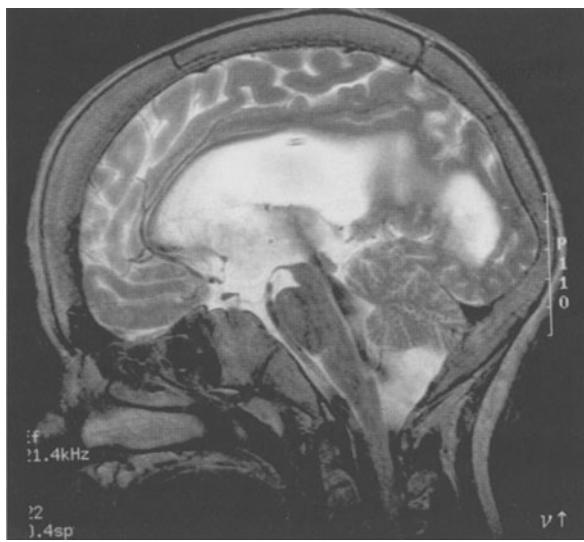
A 2 year-old boy with moderate cerebral atrophy with dilated ventricles. The sagittal T2-weighted MRI scan shows the flow void phenomenon in the aqueduct, fourth ventricle, and vallecula due to increased velocity of CSF (black)
